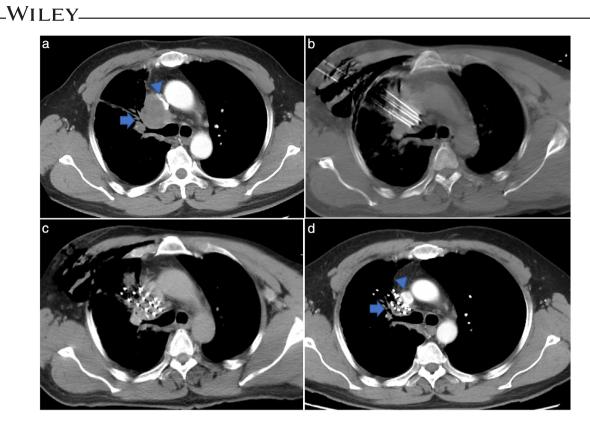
Case 1. (a) Contrast enhanced computed tomography (CT) showed mediastinal metastatic lymph node recurrence from lung cancer after surgery and systemic therapy. The superior vena cava (triangle) and right bronchus (arrow) were compressed. (b) Multiple 18 gauge needles were inserted into the tumor accurately under CT guidance. (c) Iodine-125 seeds were implanted into the tumor with satisfactory distribution. (d) A CT scan six months after brachytherapy showed that the tumor had disappeared and the compressed superior vena cava (triangle) and right bronchus (arrow) were relieved
